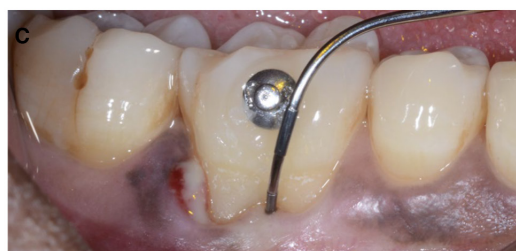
A–C, Clinical and radiographic scenarios of a combined infrabony and interradicular defect (i.e., increased pocket probing depth, furcation involvement, bleeding on probing, suppuration, and radiographic evidence of alveolar bone destruction).
